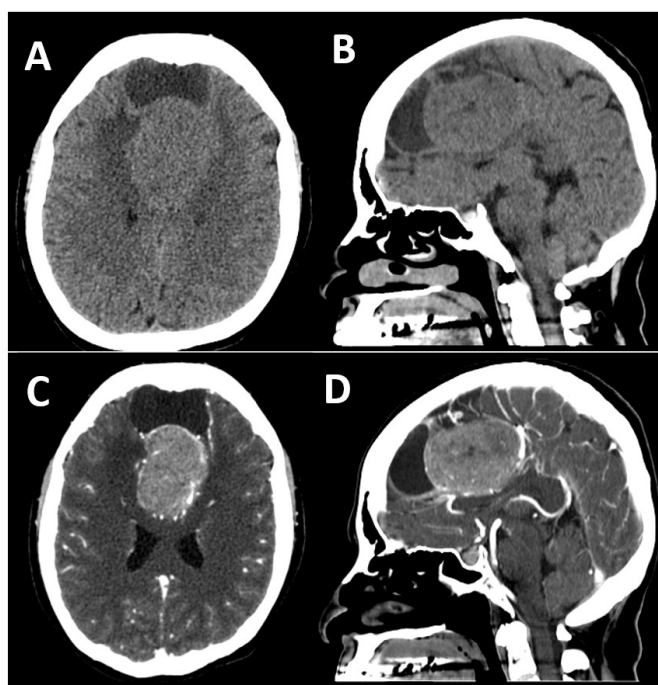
Non-contrasted CT scan in axial (A) and sagittal (B) views showing a heterogeneous subfalcine lesion. After contrast administration, the axial (C) and sagittal (D) views show a rostral cystic component and heterogeneous enhancement of the caudal solid component.
